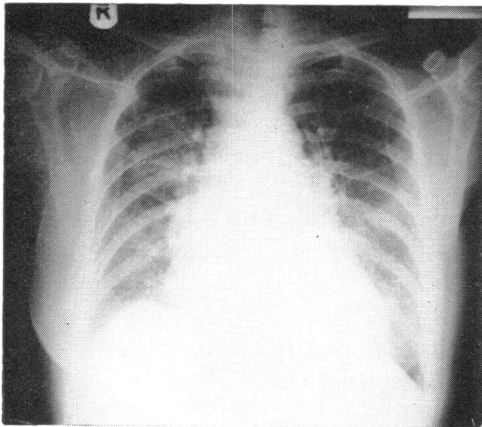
Chest x-ray on admission showing cardiomegaly and pulmonary congestion.
